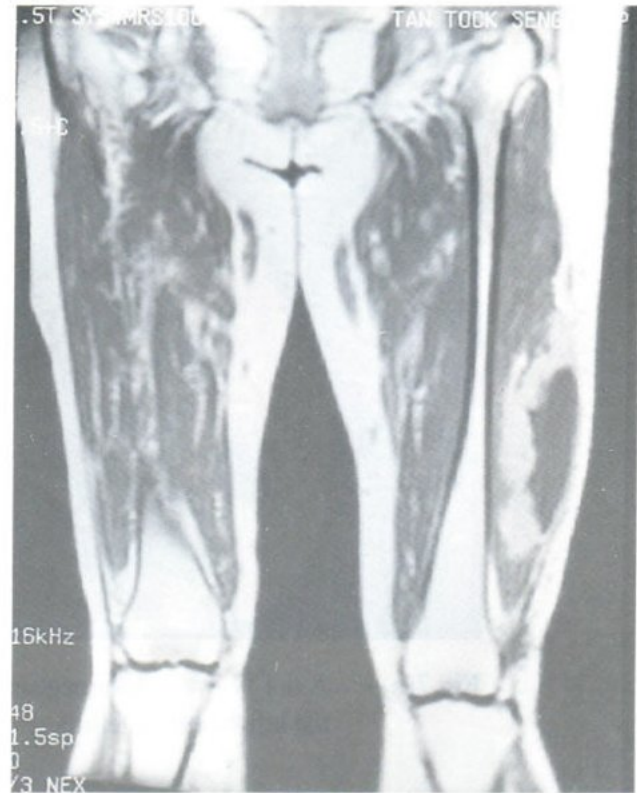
(c) Gadolinium enhanced coronal T2-weighted image shows enhancement of the wall of the abscess.
